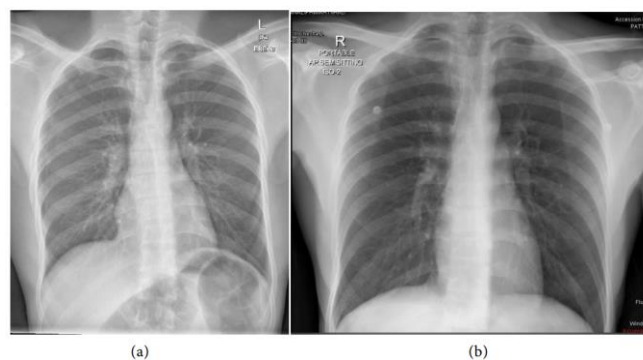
(a) Showing chest radiograph (PA view) upon admission revealing right-sided mild to moderate pneumothorax; (b) Showing chest radiograph (PA view) upon discharge with a reduction in size of small right-sided pneumothorax.
